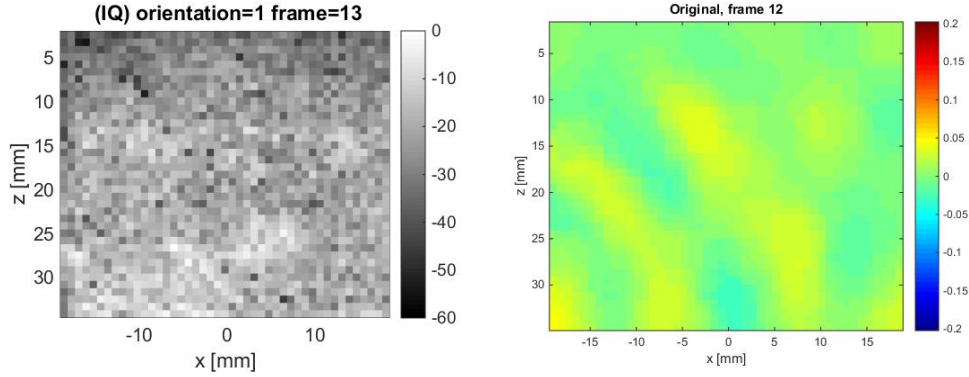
A frame of beamformed data (left) and a frame of the velocity field calculated by Tissue Doppler Imaging
